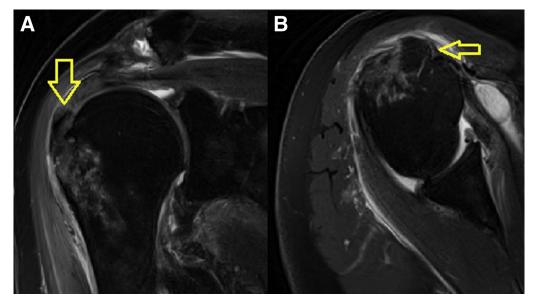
Magnetic resonance imaging of the right shoulder. (A) Coronal view showing greater tuberosity displaced fracture. (B) Sagittal view showing greater tuberosity displaced avulsion fracture.
